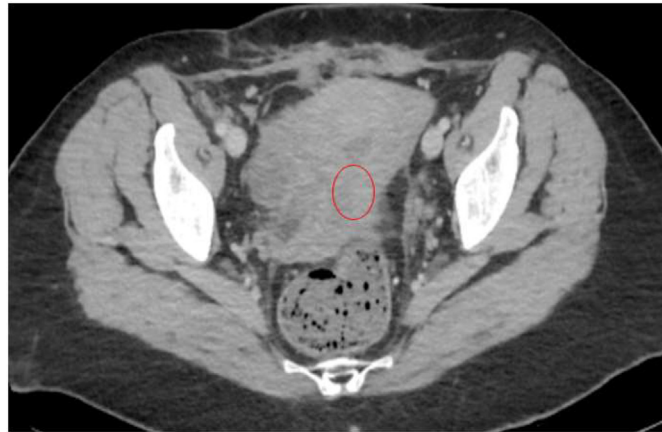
CT pelvic scan with contrast showing a complete disappearance of the pseudo aneurysm (red circle reveals the previous location of the pseudoaneurysm).
